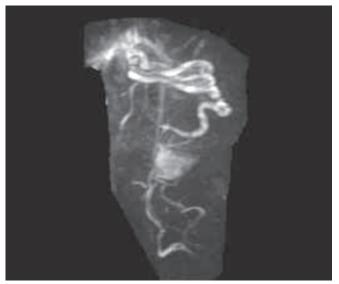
Umbilical cord and fetal vessels by magnetic resonance imaging angiography. Fetal heart and great vessels are delineated clearly. This image reveals that cord coiled three times around fetal abdomen
